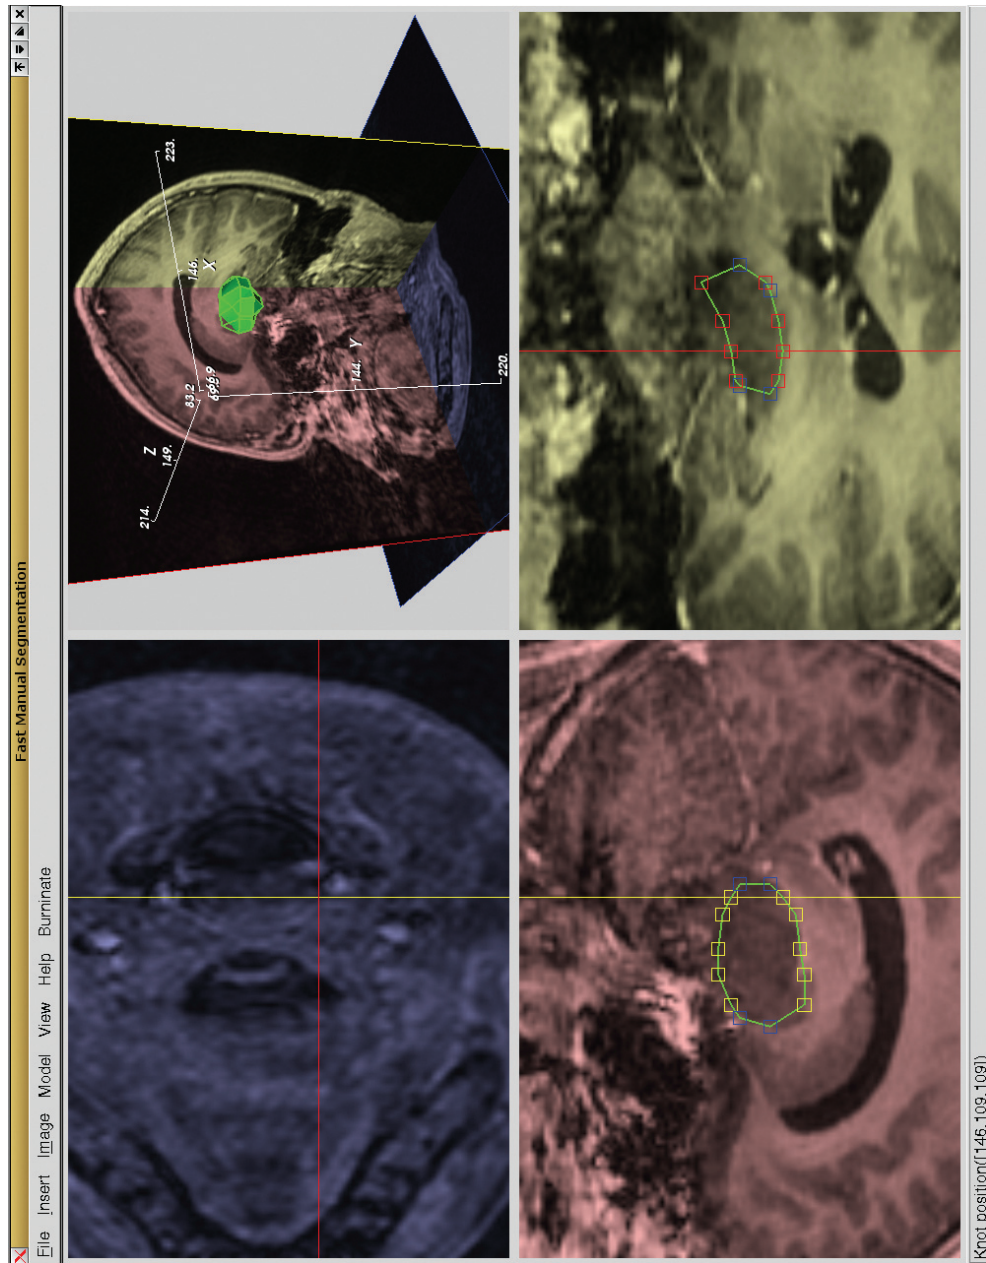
Segmentation of a tumor located in the brain (MRI dataset). The volume of the model of the tumor is  $12.4\text{cm}^3$ .
